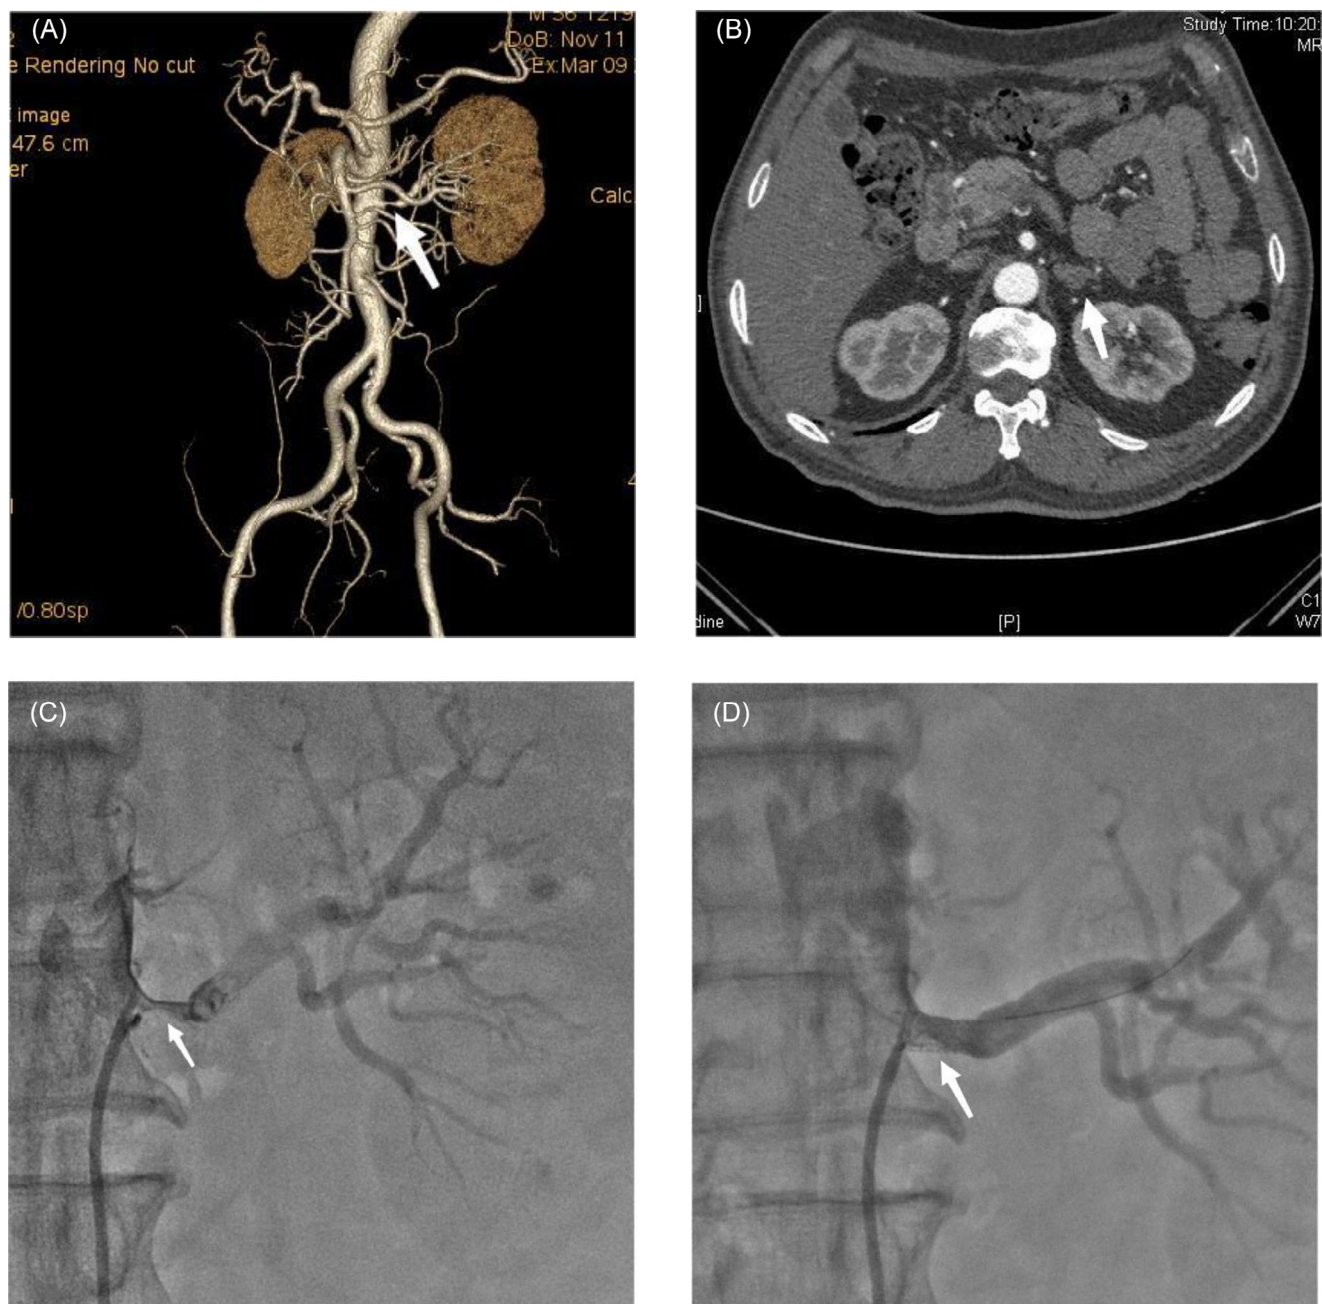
Imaging Manifestations of Renal Artery Stenosis Combined with Primary Aldosteronism. (A) Computed tomography (CT) of the renal artery showing 90% stenosis of the left renal artery (B) CT of the renal artery showing a left adrenal nodule of approximately 13 mm in size. (C) Renal angiography revealed 90% stenosis of the left renal artery. (D) Dynamic 6 ×15 mm renal stent implanted into the left renal artery.
